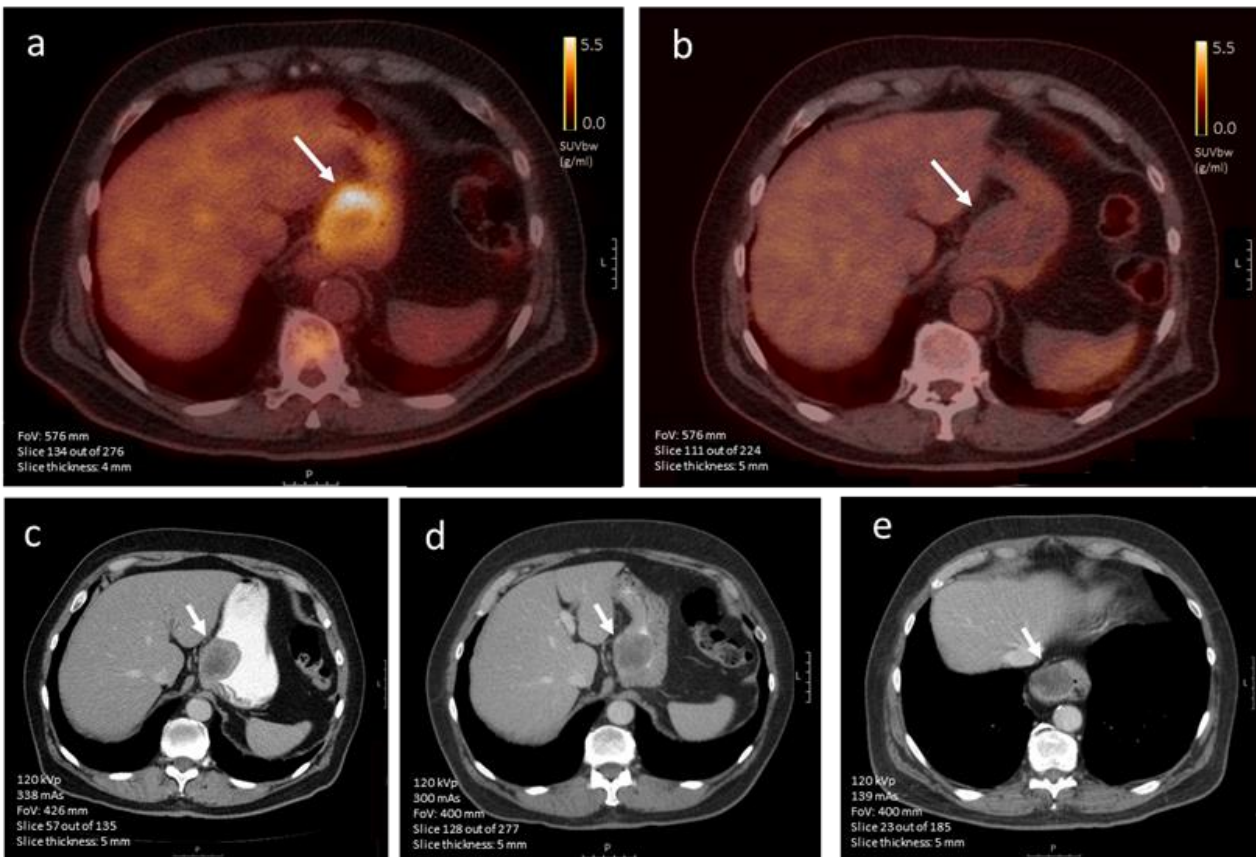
(a-e). Axial [^{18}F]FDG-PET images of a 71-year-old male diagnosed with a primary gastric GIST a) before treatment induction and b) after about three months of TKI treatment, where the standardized uptake value (SUV) is normalized. Corresponding contrast-enhanced CT imaging visualizing the same lesion (arrow) c) at diagnosis and after d) 2.5 months and e) 6.5 months of imatinib treatment, showing minimal to no change in tumor size. In the last image, the intrathoracic tumor location is caused by a sliding hernia.
